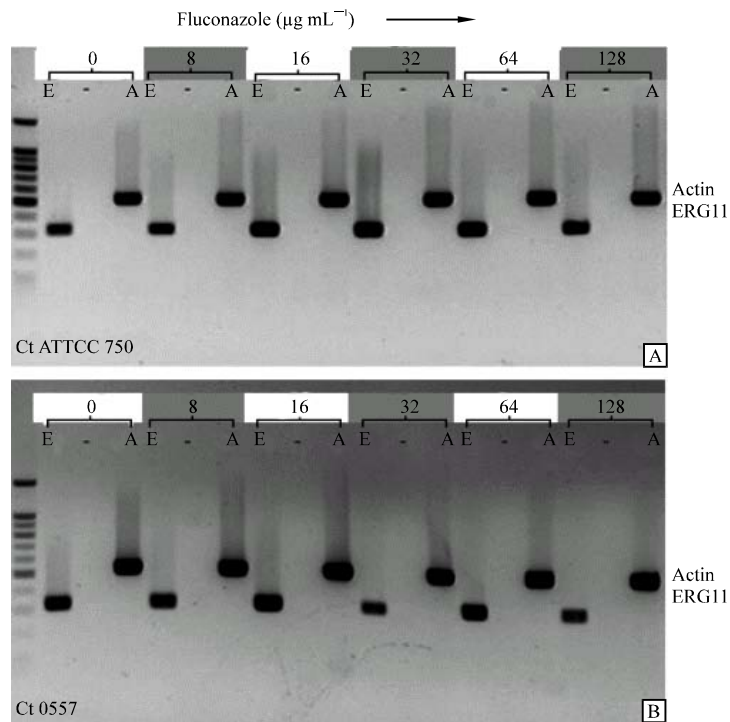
RT-PCR analysis of ERG11 and Actin genes for drug susceptible *Candida tropicalis* CT ATCC 750 (A) and drug resistant isolate Ct0557 (B) after induction with different fluconazole concentrations. ['E' = ERG11, '-' = without MMLV reverse transcriptase, 'A' = Actin]
